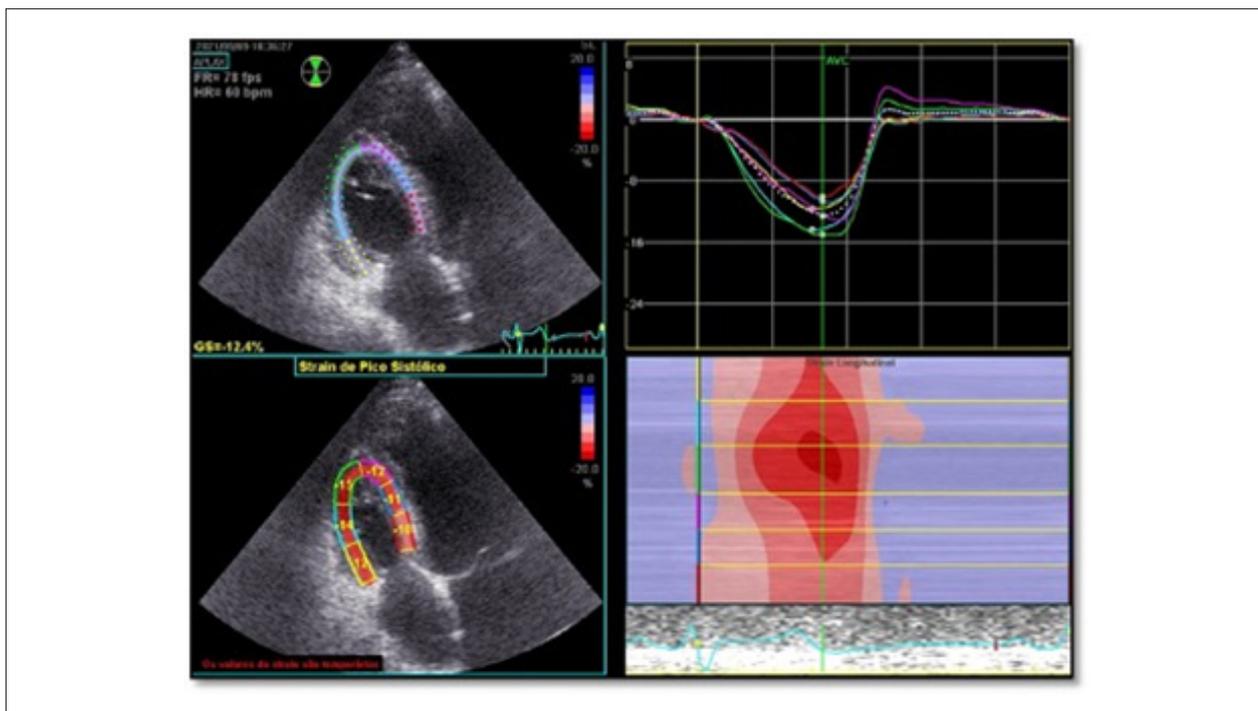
Apical four-chamber view (focused on the right ventricle); quantification of right ventricular strain by speckle-tracking echocardiography showing abnormal global and free wall strain values (12.4% and 13.6%, respectively).
